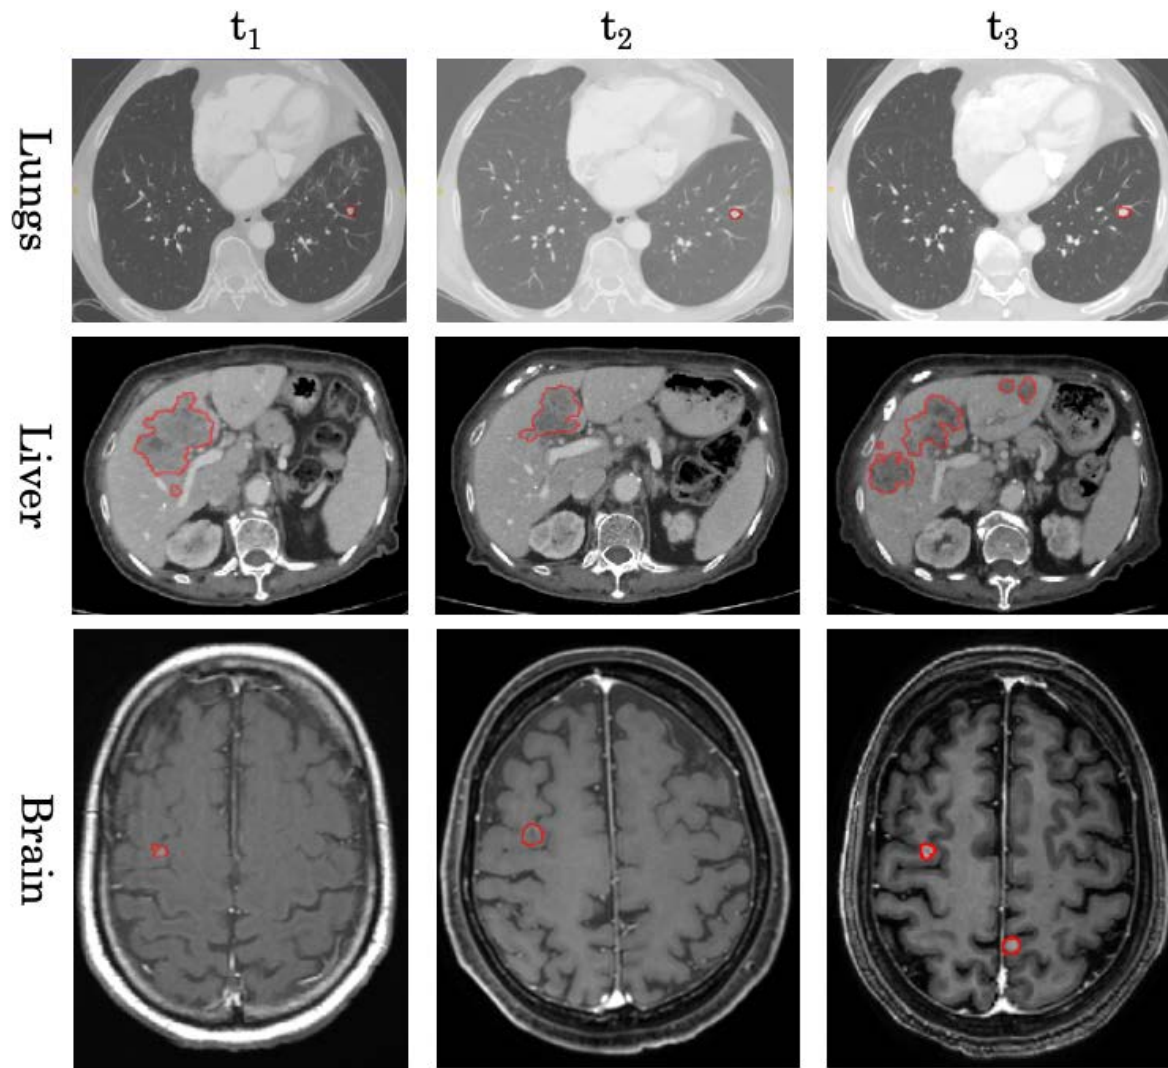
Example of axial slices of three consecutive scans (taken at t_i) of lungs, liver and brain, containing cancerous lesions. The lungs are scanned with a chest CT, the liver with a contrast-enhanced abdomen CT and the brain with a T1, Gadolinium weighted MRI scan. The lesions in the scans were manually annotated by expert radiologist and their contour is shown in red. Note the different temporal evolution of the lesions in the three examples: for the lungs a finding appear in all the images, consisting in the same lesion. For the liver, the lesion merges and shrinks between t_1 and t_2 , and split and expands between t_2 and t_3 . In the brain images, the same lesion is persistently seen in all the three scans and a new lesion appears at t_3 .
